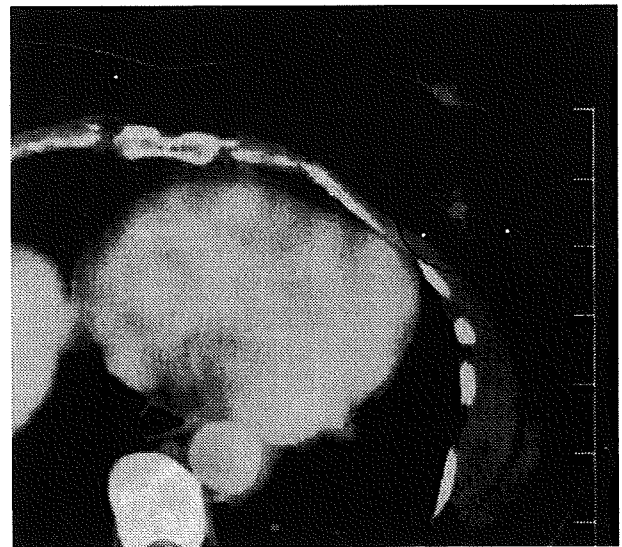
PET-CT showed faint uptake of fluorodeoxyglucose (FDG) with a standard uptake value (SUV) of 1.06 in CD regions, or upper and lower outer quadrants (red circle)
